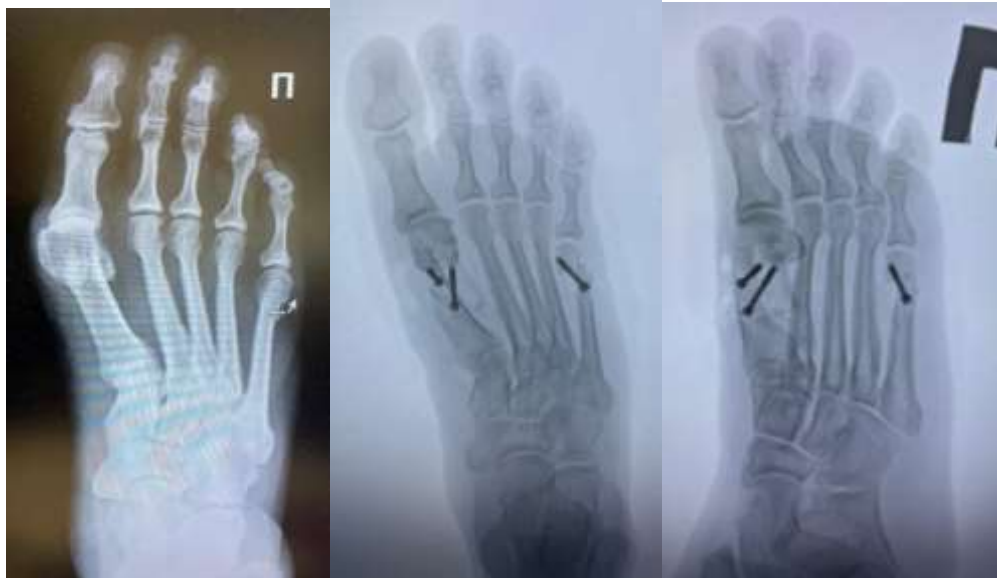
Pre and postoperative radiograph of Patient A with PRGF The above figure describes pre and post-op radiographs demonstrating hallux valgus and Tailor’s bunion and its correction by Scarf and Wilson osteotomy. Here, intraoperative infiltration of PRGF has taken place.
